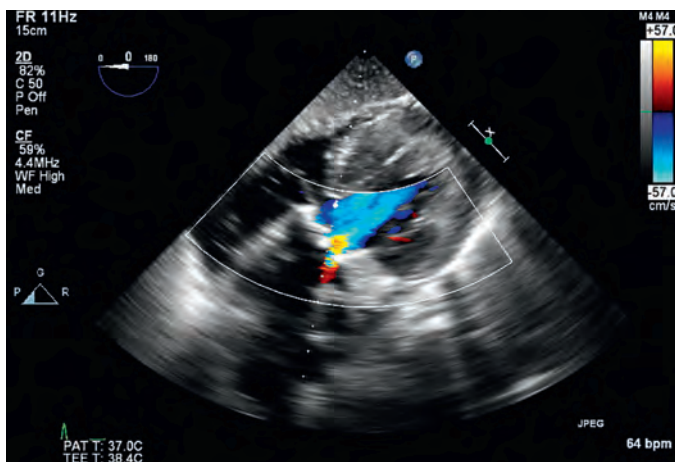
Lining up the cursor: deep transgastric view. Superimposition of color-flow Doppler across the stenotic aortic valve allows for a more accurate identification of the limited aortic valve opening. With this information, the cursor may be more easily placed to obtain a continuous-wave Doppler spectrum.
